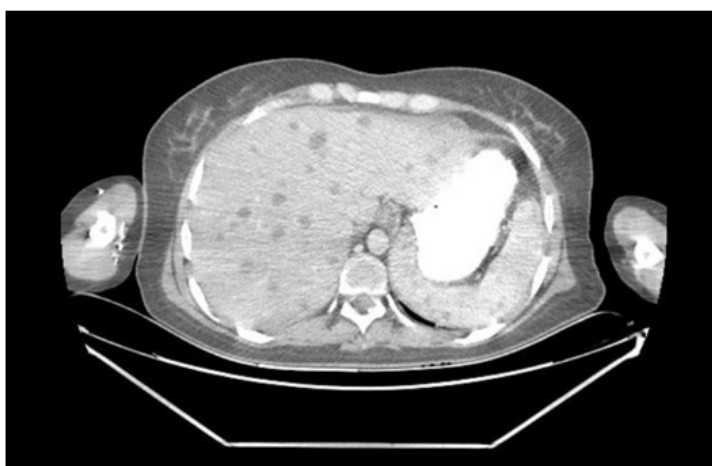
Abdominal computed tomography with multiple hepatosplenic lesions.
